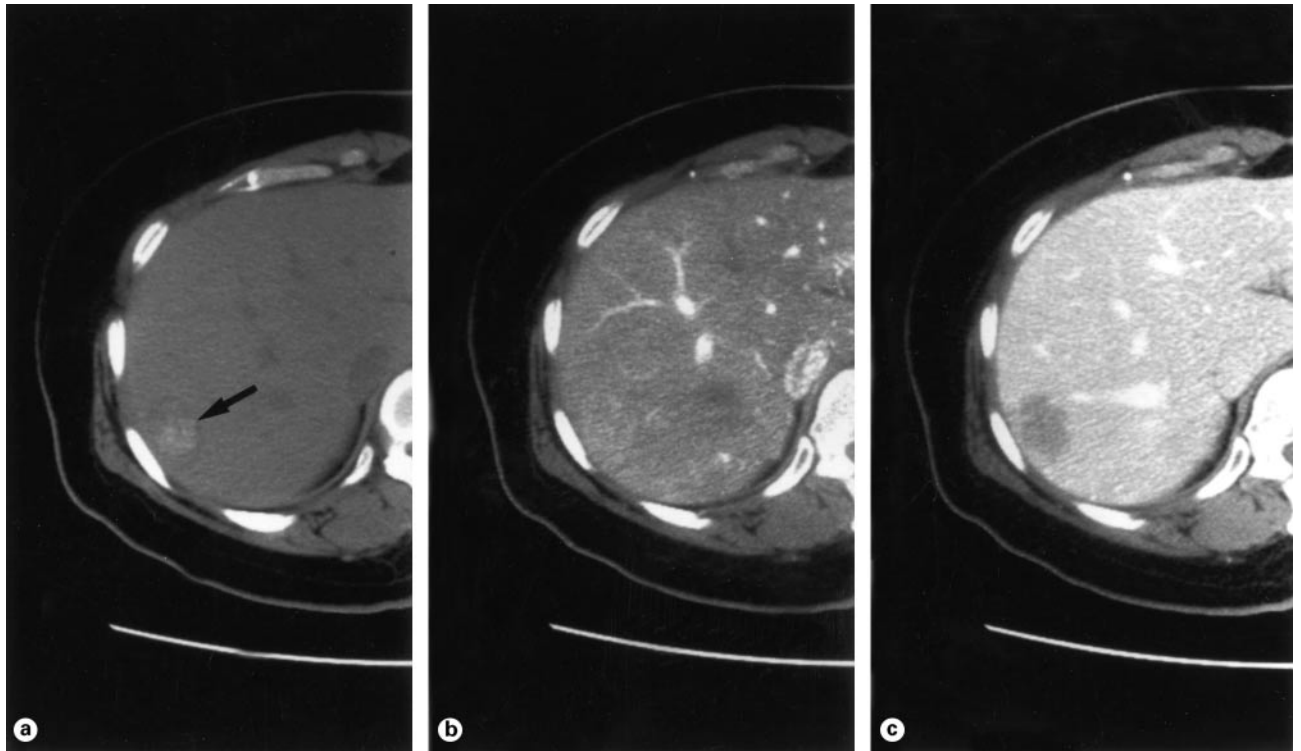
Metastatic liver tumor (colon cancer) in a 53-year-old woman. On unenhanced CT (a), calcification is observed in the tumor (arrow) which is relatively characteristic to metastatic liver tumor from colon cancer. The arterial phase image (b) fails to depict the tumor because the liver parenchyma is enhanced to some extent and become isoattenuated compared with the tumor. On the portal venous phase image (c), the tumor appears hypoattenuating relative to liver parenchyma. On SPIO-enhanced T2*-weighted MRI (gradient echo, 150/9.7/60) (d), the tumor is visualized as area with a higher signal than the surrounding liver parenchyma due to decreased uptake of SPIO in the tumor (arrowhead).
